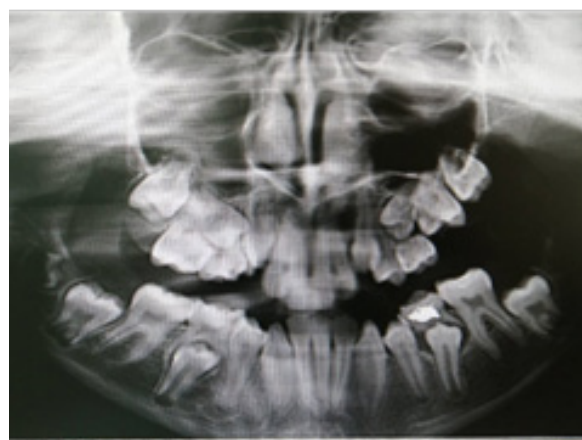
Panoramic radiograph of a 12-year-old patient before treatment
